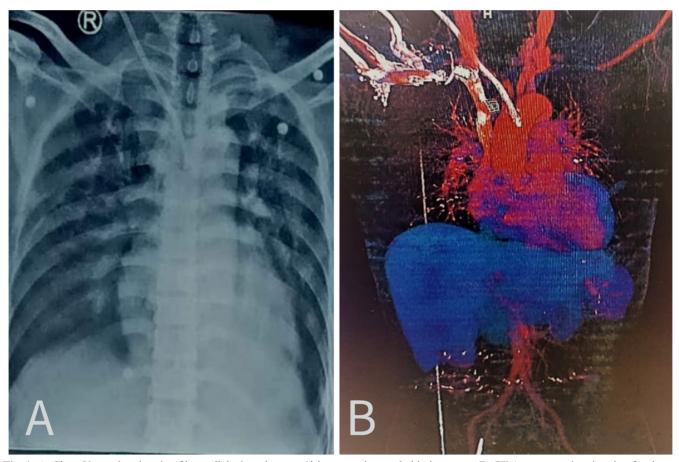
A. Chest X-ray showing tip of hemodialysis catheter at 4th intercostal space behind sternum. B. CT Aortogram showing tip of catheter piercing arch of aorta in mid-intra-luminal region.
